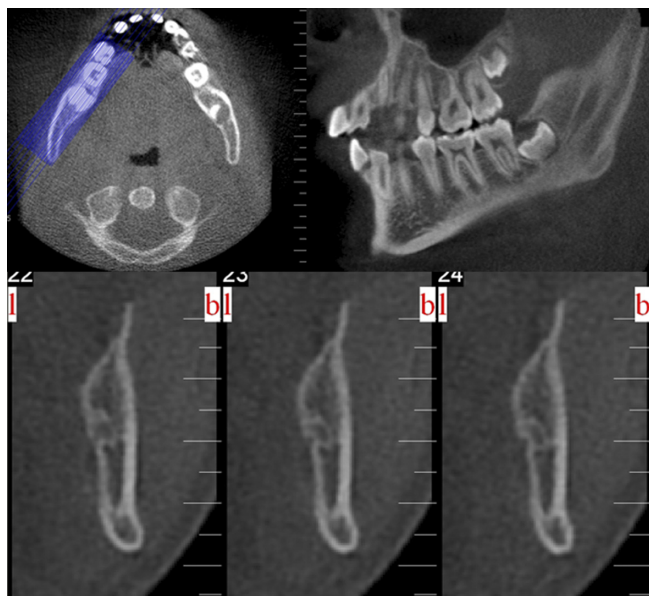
Reconstructed axial, cross-sectional, sagittal CBCT images used for detection and measurement of the bifid mandibular canals.
